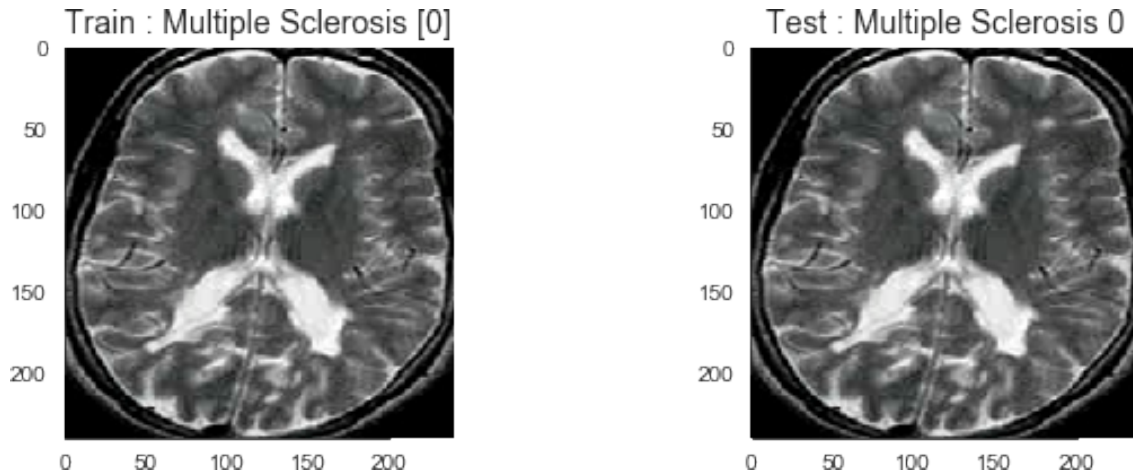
Classified MS affected brain MRI
